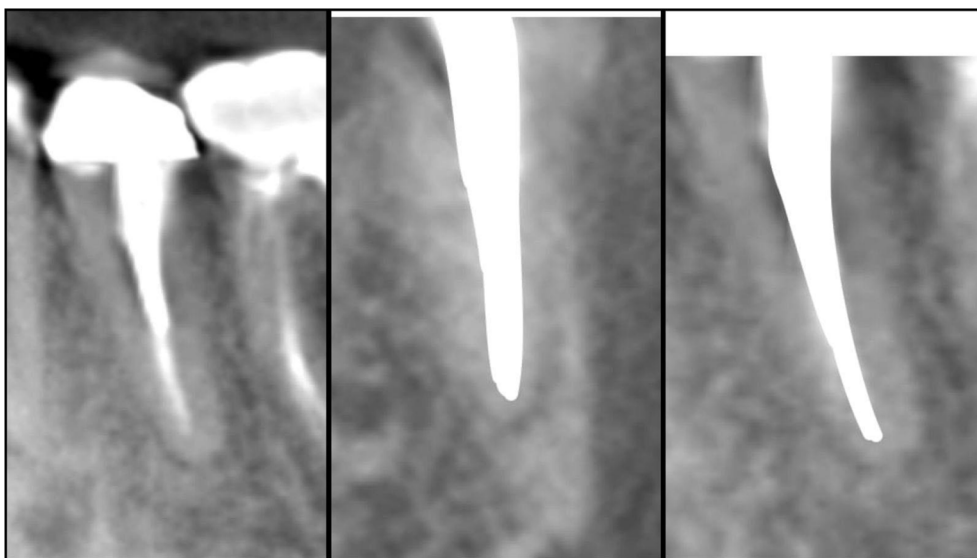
An example of a tooth with a metal intra-radicular post without a periapical radiolucent lesion (coronal and sagittal). The two independent evaluators disagreed on this case. A third opinion was taken, and the absence of apical periodontitis was decided
